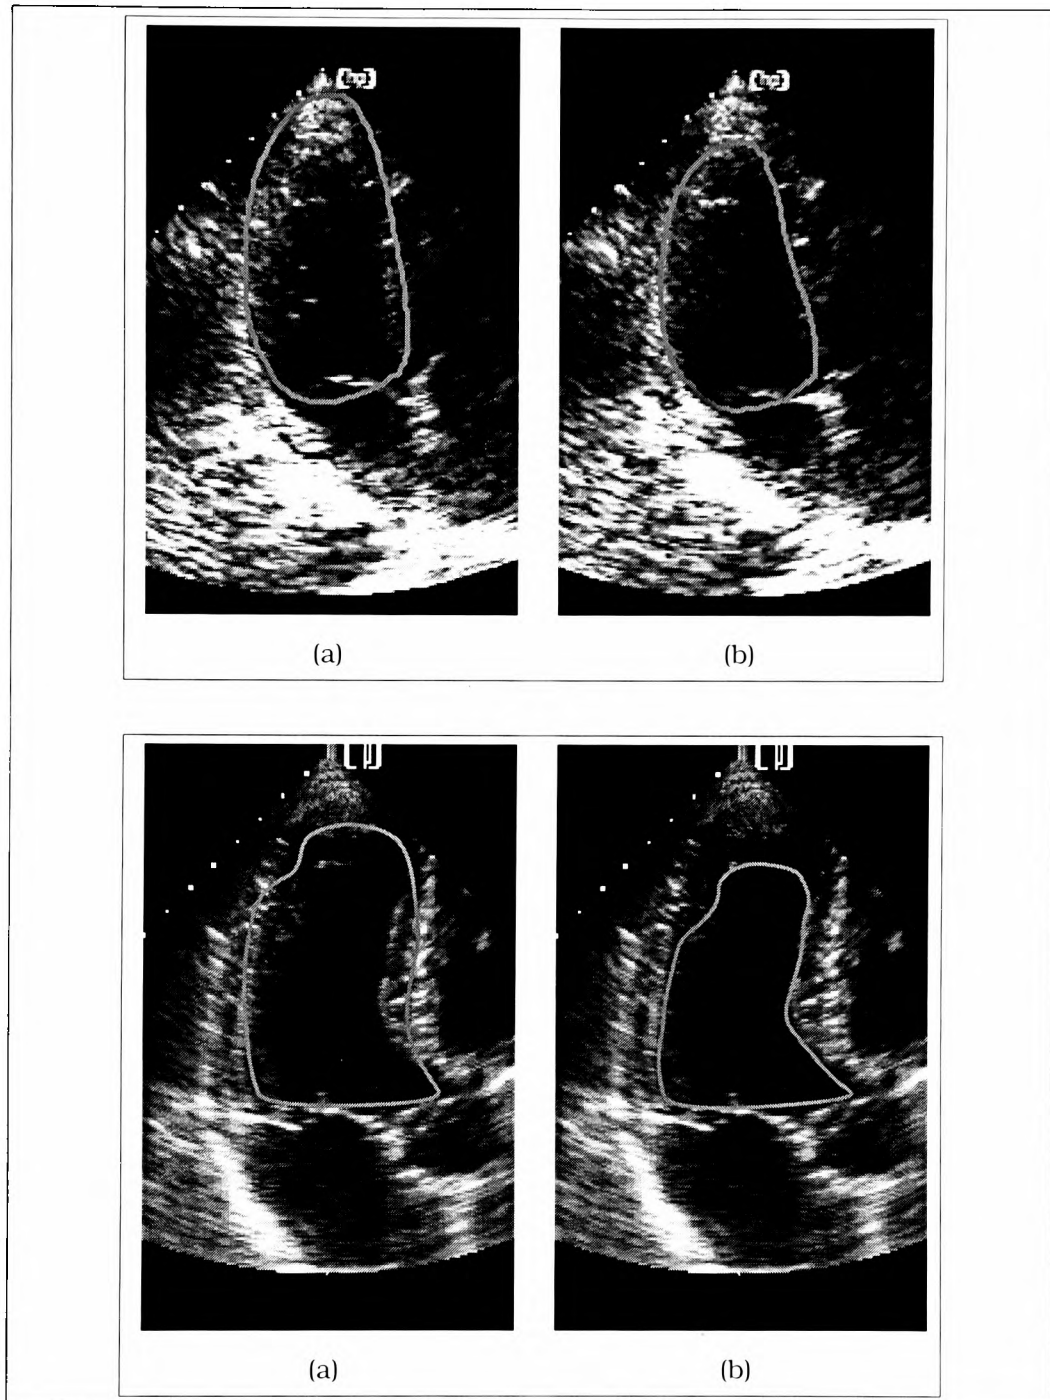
Shape-space tracking. Echocardiographic tracking using an (a) *affine* and (b) *PCA* shape space on two different hearts (top and bottom). The affine shape-space is unable to deal with the non-rigid deformations of the left ventricular boundary. In contrast, the finely tuned PCA shape-space, which is learnt from a training set of example contours, allows the contour to deform in accordance with heart motion. (Top Pair) The data in 10 second image sequence in the top example, was recorded on VHS video and then digitised. There are approximately 22 frames per cardiac cycle. 14 control points are used with a canny edge detector. The features chosen are the measurements with the strongest response to the filter. (Bottom Pair) The data in 3.5 second image sequence in the top example, was digitally captured and stored on optical disk. There are approximately 81 frames per cardiac cycle. 24 control points are used with a local phase detector (see Section 5.3.1). The features chosen are the measurements with the strongest response to the filter.
